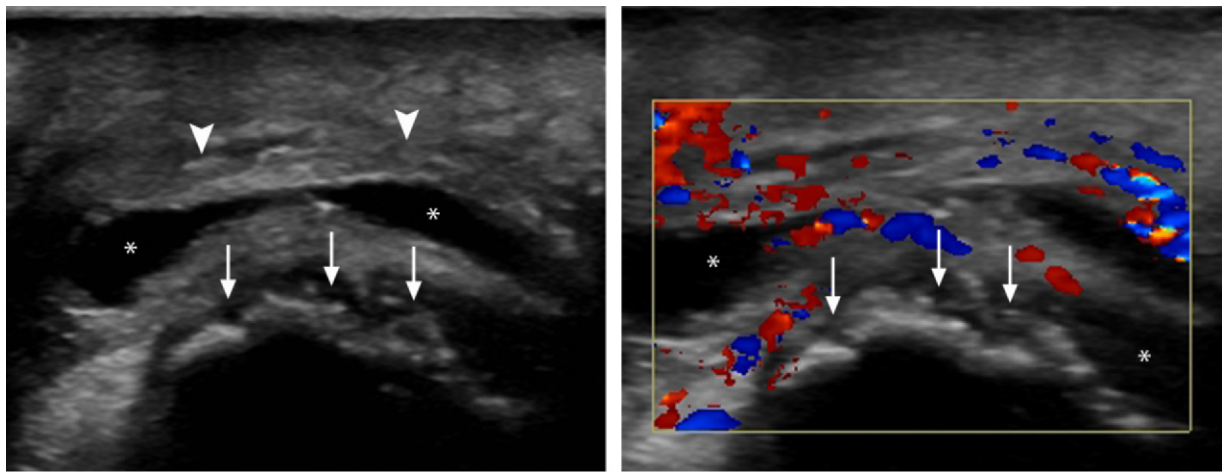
Olecranon bursitis secondary to gout in a 50-year-old man. (a) Transverse US image shows a complex hypoechoic fluid collection (*) with synovial thickening (arrowheads) and cortical irregularity with hyperechoic foci (arrows), which are consistent with osseous erosions and crystalline deposition from gout. (b) Color Doppler image shows hyperemic synovium. * = complex hypoechoic fluid collection, arrows = osseous erosions and crystalline deposition from gout.
